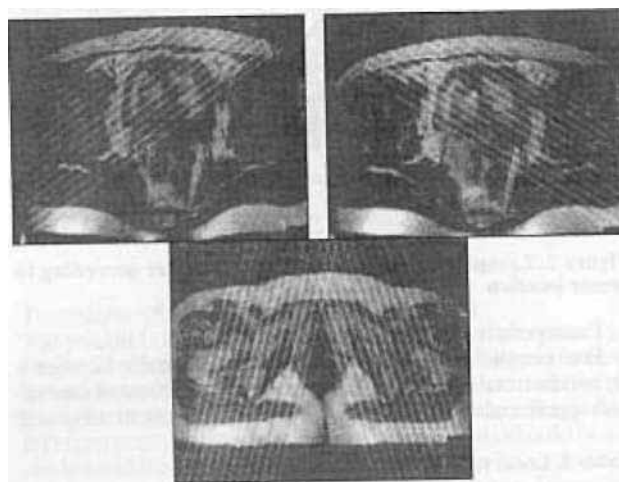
Preoperative MRI by two oblique method
